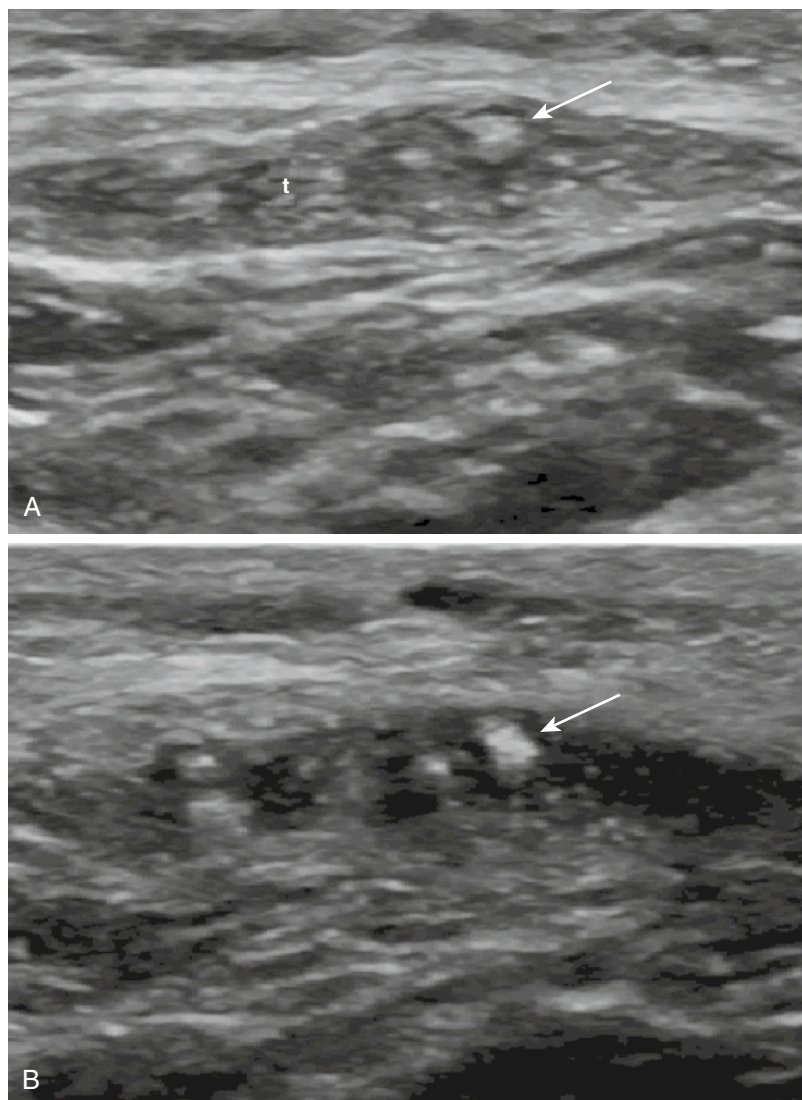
CHRONIC GOUT. Transverse views of the patellar tendon (t) obtained with different probe inclinations that were perpendicular to the tendon (A) and with the ultrasound beam direction changed to reduce tendon echogenicity due to anisotropy (B). The arrows indicate intra-tendinous urate deposits, whose visualization is enhanced by the decrease of the surrounding tendon echogenicity.
